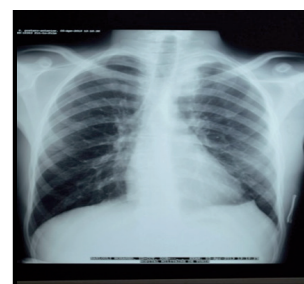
Post operation frontal chest radiography
